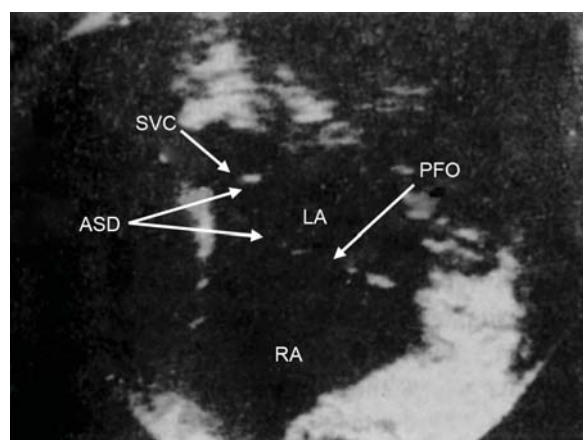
Echocardiography (two-dimensional) of a sinus venosus atrial septal defect.
